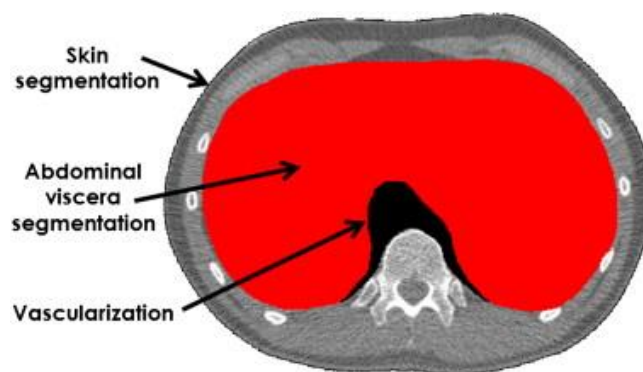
The segmentation of the abdo-thoracic viscera on a CT image by using the VRMed software. The figure originated from the paper of [Hostettler et al. \(2010\)](#).
